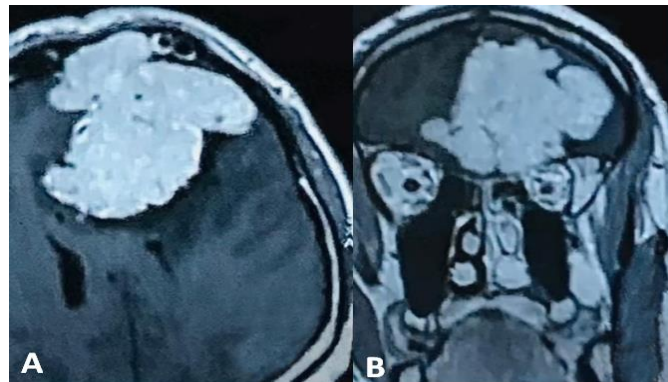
MRI in transversal (A) and coronal (B) view showed a large extra-axial mass on the anterior skull base with extension to the left frontal lobe, with homogeneous contrast uptake and significant perilesional oedema
